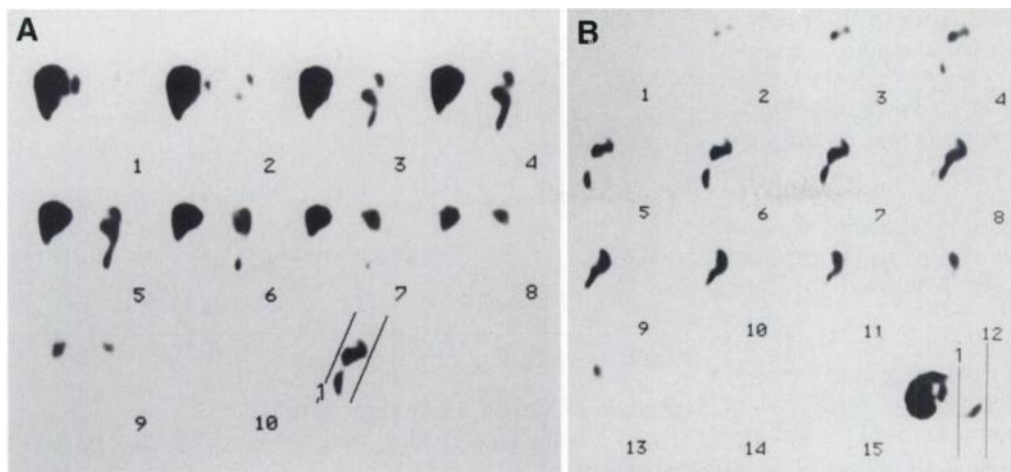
Selected (A) oblique and (B) sagittal slices of the liver-spleen SPECT. The original coronal slices were slightly reoriented to display better the origin of the anomalous splenic tissue at the lower pole of the spleen. With SPECT no further image enhancement is necessary.
